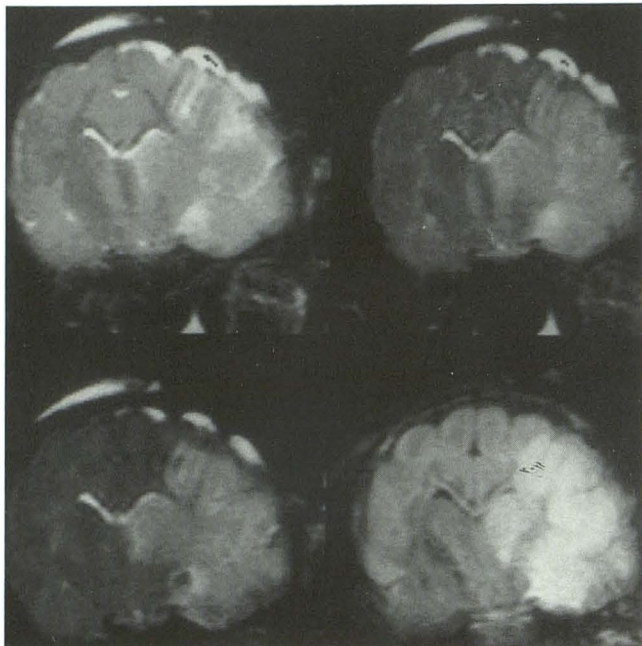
5–7 hr after MCA occlusion, hyperintensity was observed in the same anatomic regions on T2-weighted (*upper left*), diffusion-weighted (*lower right*), and magnetic susceptibility-enhanced (*upper right*) images 15 min after injection of 0.5 mmol/kg Dy-DTPA-BMA and 15 min after 1.0 mmol/kg Dy-DTPA-BMA (*lower left* image). On precontrast T2-weighted MR image, signal intensity ratios increased by 109% in the ectosylvian gyrus, 18% in the middle temporal gyrus, and 39% in the caudate nucleus. The corresponding MR signal intensity ratios increased after injection of 0.5 mmol/kg Dy-DTPA-BMA by 83%, 34%, and 118%, respectively. After 1.0 mmol/kg Dy-DTPA-BMA, signal intensity ratios increased by 168%, 51%, and 211%, respectively. Finally, on the diffusion-weighted MR image, the corresponding increases in signal intensity ratios were 66%, 113%, and 61%, respectively.
